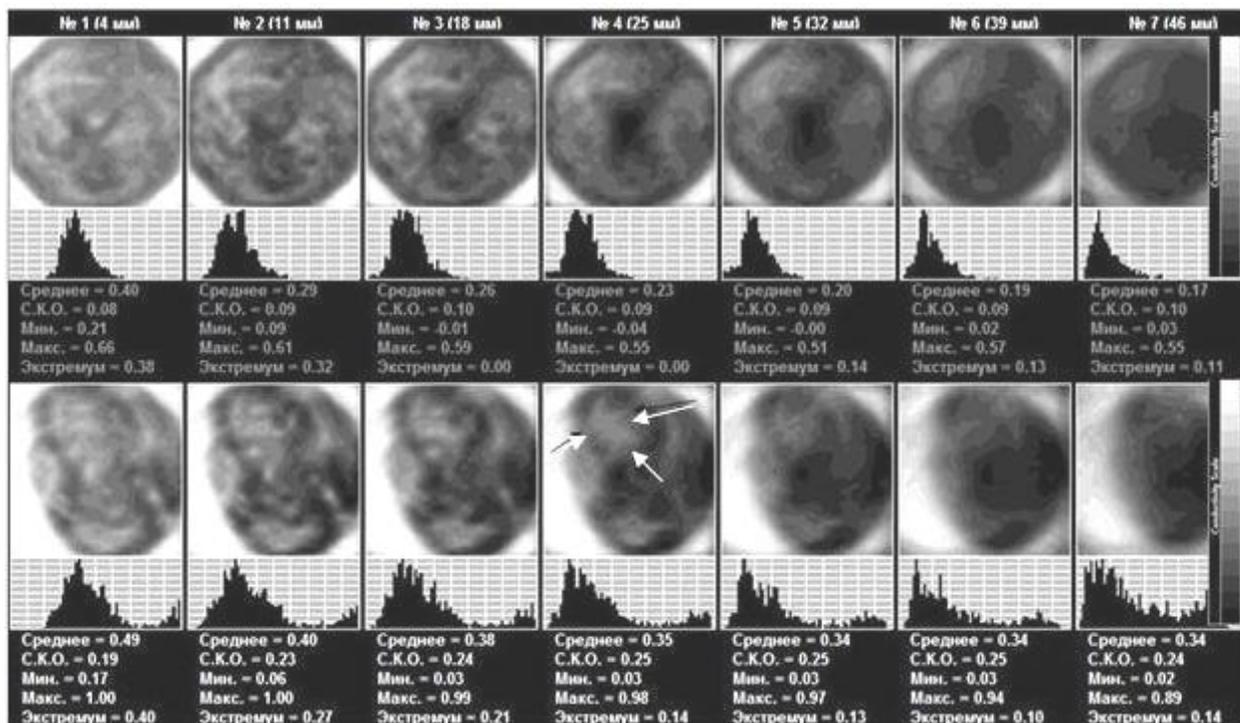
EIM. EIM. Top row – left gland. Fibrous type of mammary gland structure. Lower row – right gland. Fibrous type of mammary gland structure. Outer segment. At 12 o'clock position there is an irregular-shaped inhomogeneous iso-impedance formation measuring 37x24 mm with a hyper-impedance contour. ULTRASOUND: In the upper-outer segment of the right gland, there is a formation with blurred contours and vascularization, 15x20 mm in size. An enlarged lymph node can be visualized in the axillary area.
